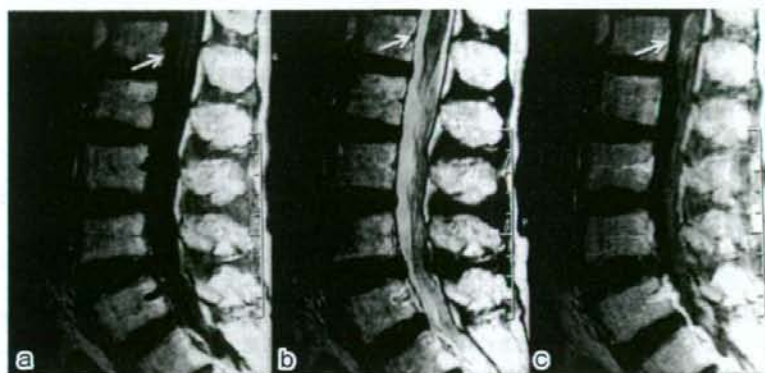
Sagittal magnetic resonance imaging (MRI) scan of the lumbosacral regions on admission shows a 9×3-mm homogenous mass with isointensity on T1-weighted images (a) and low intensity on T2-weighted image (b) indicating intramedullary hemorrhage in conus medullaris. Gadolinium-enhanced T1-weighted images demonstrates contrast enhancement of the surrounding of mass (c).
